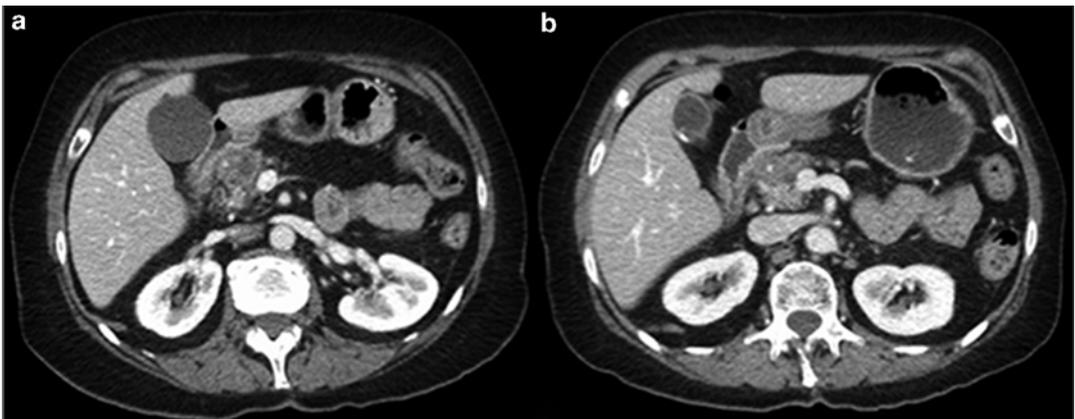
Computed tomography scan of patient with BRPC due to hepatic arterial involvement both before (a) and after (b) neoadjuvant therapy with FOLFIRINOX. The tumor can be seen encasing the gastroduodenal artery
